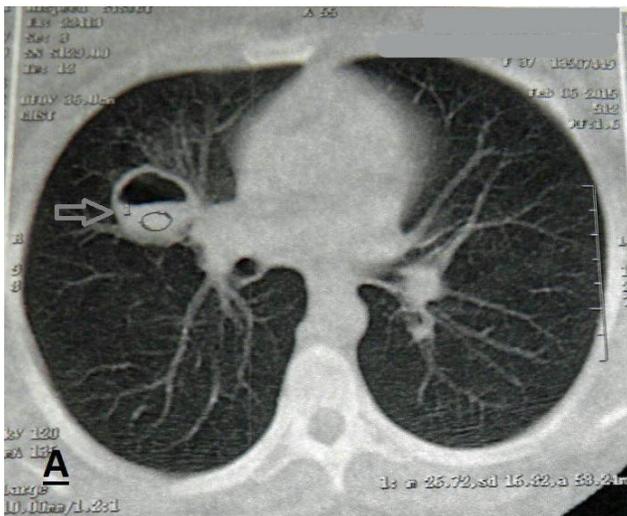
CT scans 10 months after treatment with albendazole. Right cyst is central with intra cystic fluid accumulation (A) and left cyst is peripheral and completely empty (B).
